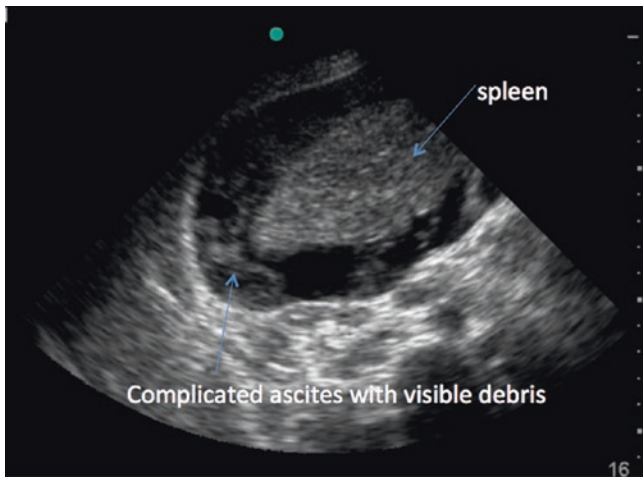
Abdominal ultrasound in a patient with ascites. In this image, the ascites is complicated and thick echogenic fibrinous material is seen in the normally echo free ascitic fluid. See also Video 37.20, in which the debris is seen, appearing as flotsam
